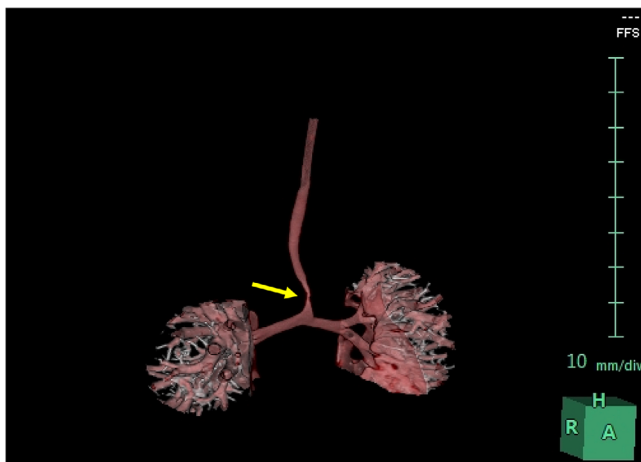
3D CT reconstructions of the airway demonstrating severe tracheal narrowing (yellow arrow)
